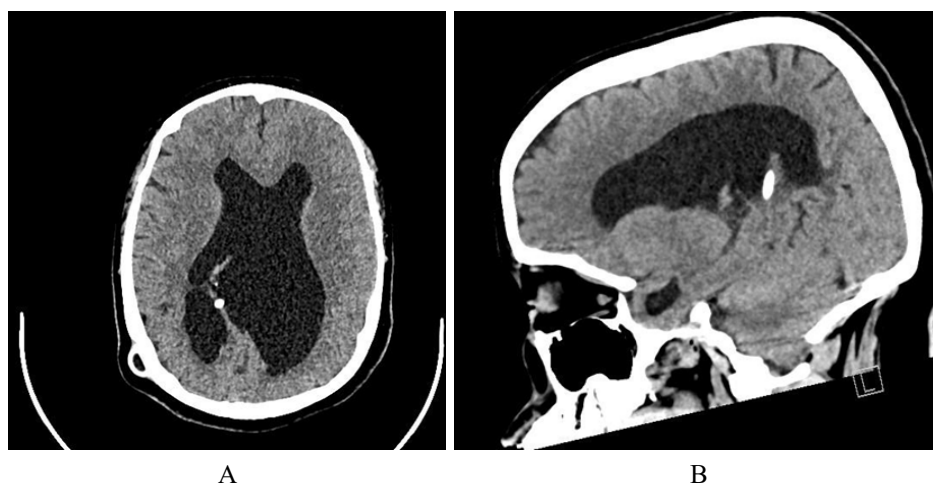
Follow-up non-contrast computed tomography (CT) of the brain obtained two years postoperatively. (A) Coronal and (B) sagittal images demonstrate redemonstration of the ventriculoperitoneal (VP) shunt with the catheter tip located posterior to the pineal gland. There is interval progression of chronic supratentorial ventricular dilatation without evidence of transependymal edema. The previously described midline cystic lesion in the pineal region is no longer discretely visualized. No intra-axial or extra-axial hemorrhage is identified. Stable Chiari type I malformation with tonsillar ectopia is noted.
